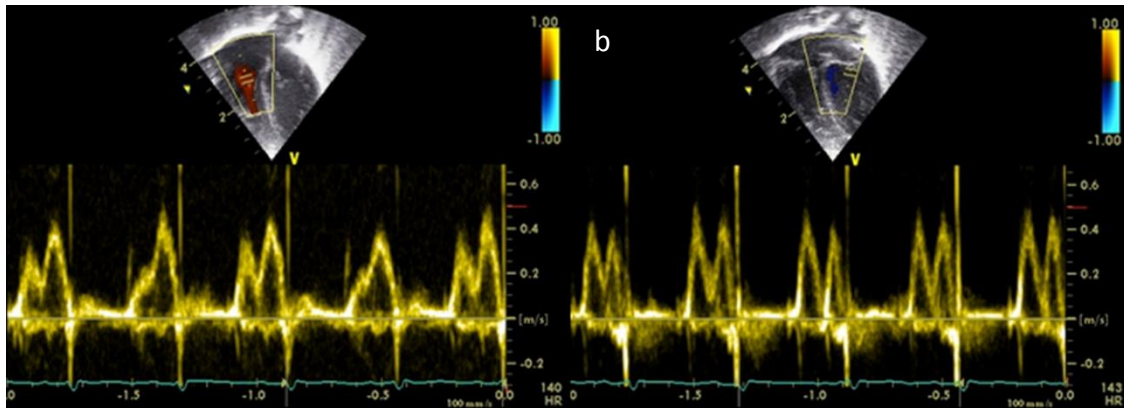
Doppler ultrasound: Tricuspid (a) and mitral (b) valve inflow in a neonatal heart visualized with colour Doppler ultrasound.
